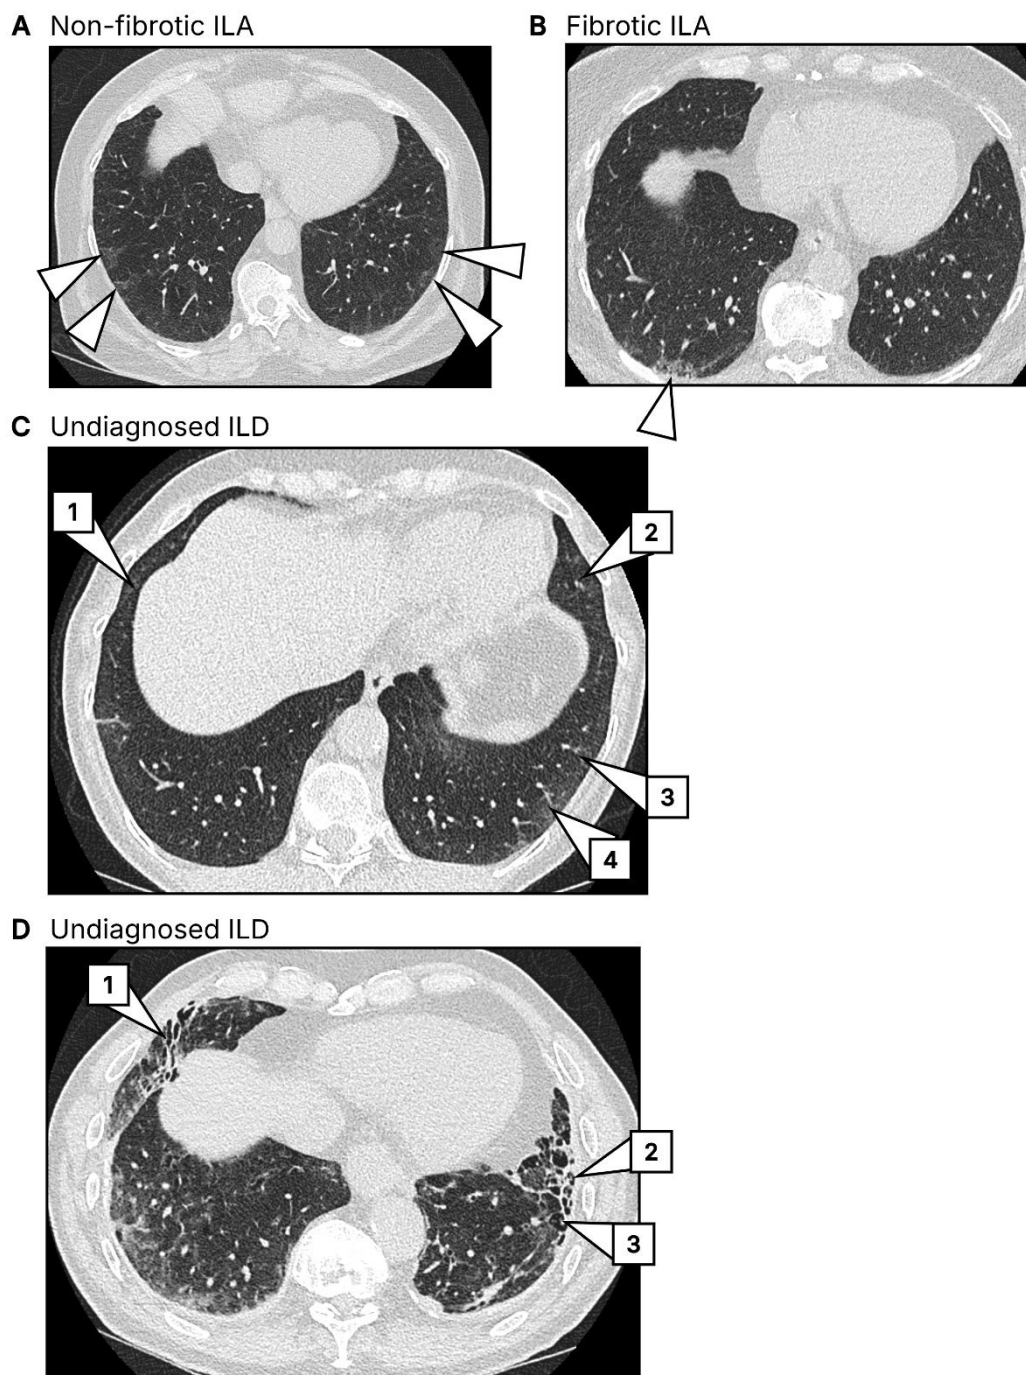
Axial CT images of cases classified by TBe score as A) non-fibrotic ILA (NF-ILA), B) Fibrotic ILA (F-ILA), and C and D) undiagnosed ILD (U-ILD). In panel A, arrows point to bilateral foci of ground glass change. In panel B, the enlarged image shows a focus of traction bronchiolectasis (arrowhead) occurring on the background
